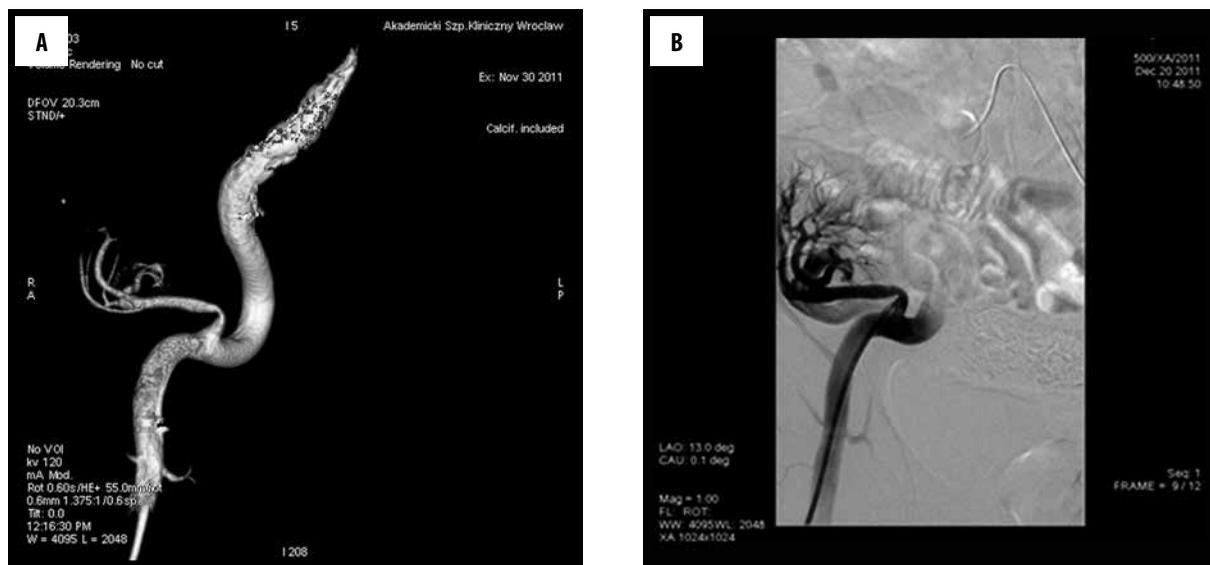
(A) Ultra-low intraarterial contrast angio-CT (volume of contrast – 6 mL). (B) DSA in the same patient performed directly prior to stenting of the renal artery in the transplanted kidney.
